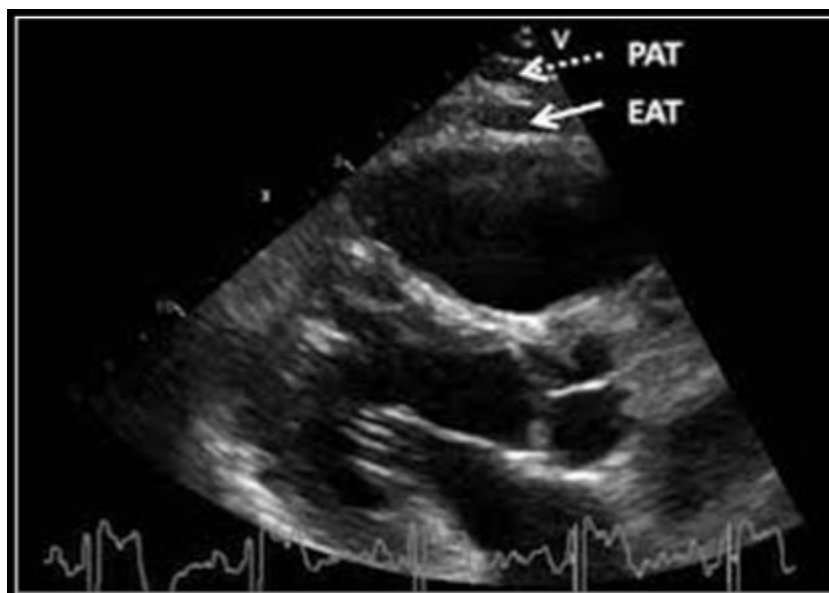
Echocardiographic measurement of epicardial adipose tissue and pericardial adipose tissue ^[10].
